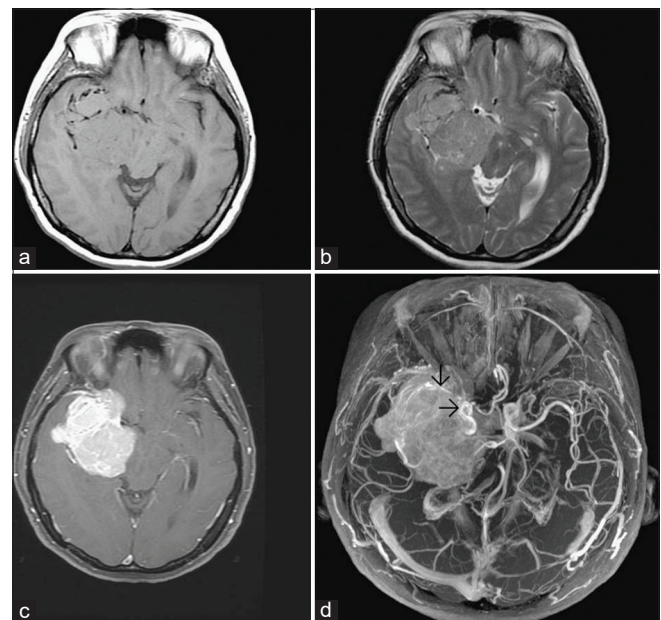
Preoperative brain MRI of case 2. Axial T1-weighted image (a) and axial T2-weighted image (b) showing a large tumor in the right side frontotemporal region, abutting the sphenoid ridge and right cavernous sinus, extension to the right basal ganglion and right side periventricular region with relative isosignal intensity on T1WI and T2WI. Axial T1-weighted image postgadolinium enhancement (c) showing good enhancement. MRA (d) partial encasement of the right middle cerebral artery and right supraclinoid internal carotid artery (black arrows).
